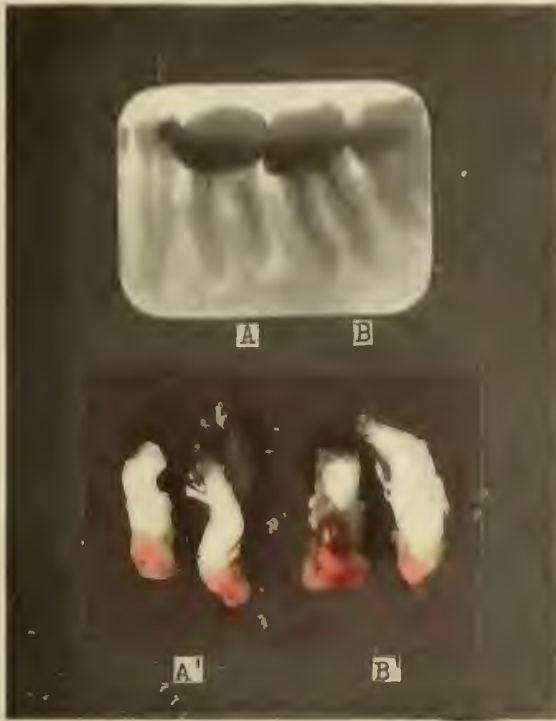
COMPARISON OF THE APPARENT WITH THE ACTUAL. A AND B SHOW, ROENTGENOGRAPHICALLY, TWO MAXILLARY MOLARS. NOTE THEIR DIFFERENCE. A' SHOWS THE PERIAPICAL GRANULOMATA ATTACHED TO THE ROOTS OF A, AND B' THE PERIAPICAL GRANULOMATA ATTACHED TO THE ROOTS OF B. THE ZONES OF RAREFACTION IN A AND B ARE OBSCURED BY ZONES OF CONDENSING OSTEITIS.
